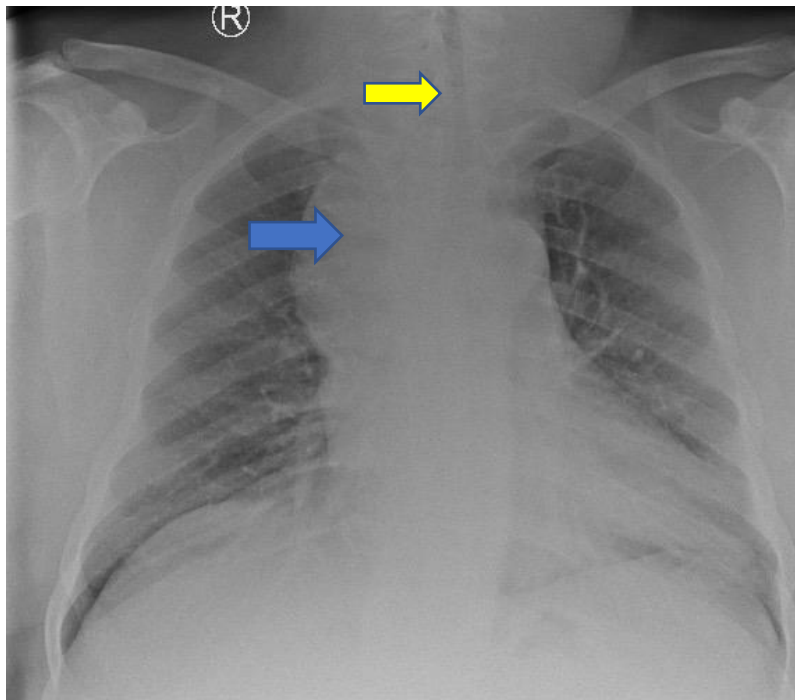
Retrosternal thyroid goitre. Plain radiograph showing widened mediastinum (blue arrow) and narrow trachea (yellow arrow).
